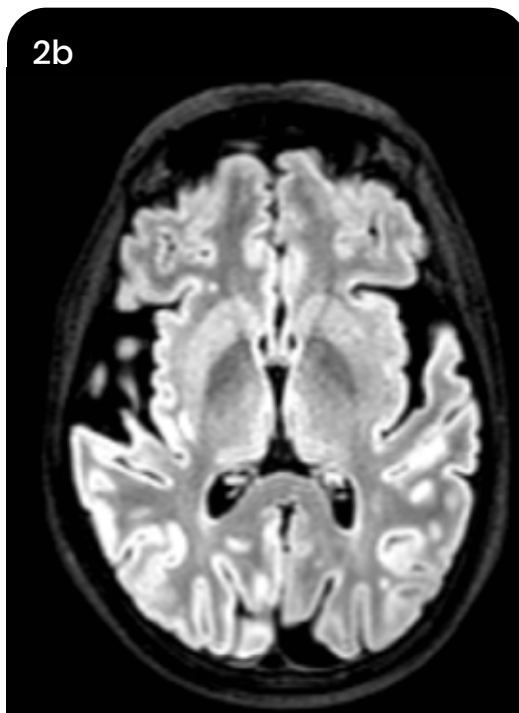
Hockey stick sign on FLAIR
